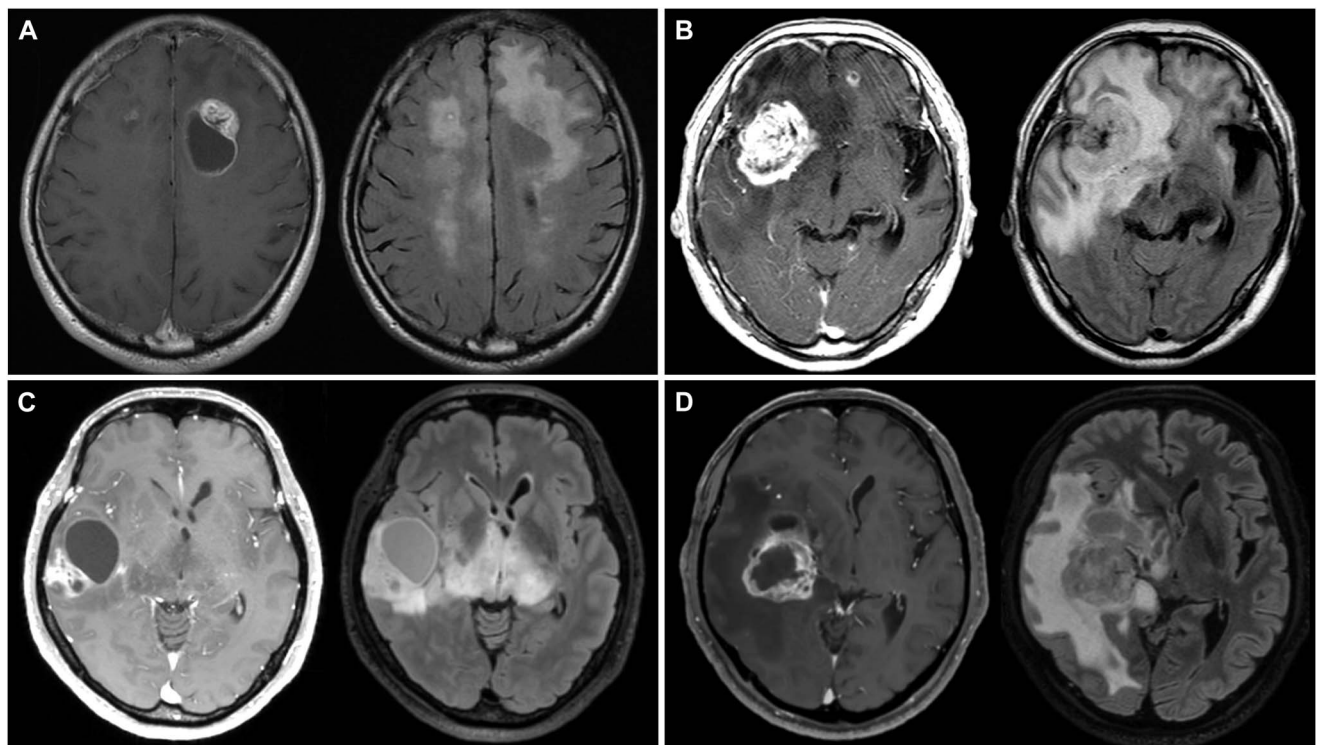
Head MRI findings. The right panel shows the axial gadolinium-enhanced T1WI, and the left panel shows the axial FLAIR image. A, and B, Cases 1 and 2 show bilateral diffusely infiltrating FLAIR hyperintense lesions and gadolinium-enhancing lesions in both cerebral hemispheres. C, Case 3 shows bilateral thalamic FLAIR hyperintense lesions and a unilateral gadolinium-enhancing lesion. D, Case 4 shows a unilateral gadolinium-enhancing lesion and a surrounding FLAIR hyperintense lesion.
